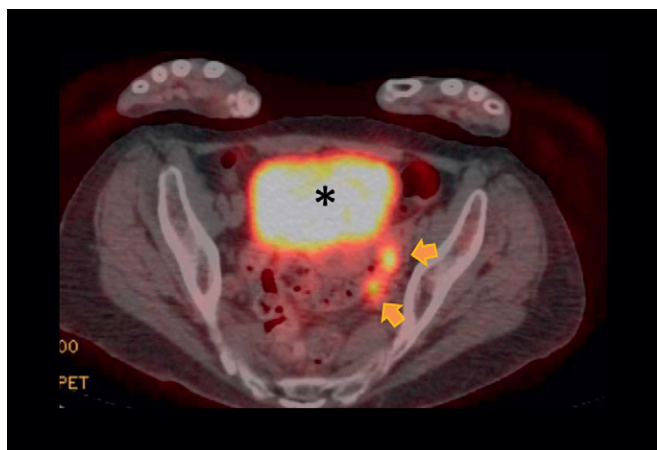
PET CT showing a small area of hypermetabolism traced by fluorodeoxyglucose in the left adnexal region (arrows). A physiological accumulation of deoxyglucose within the bladder is also apparent (asterisks).
